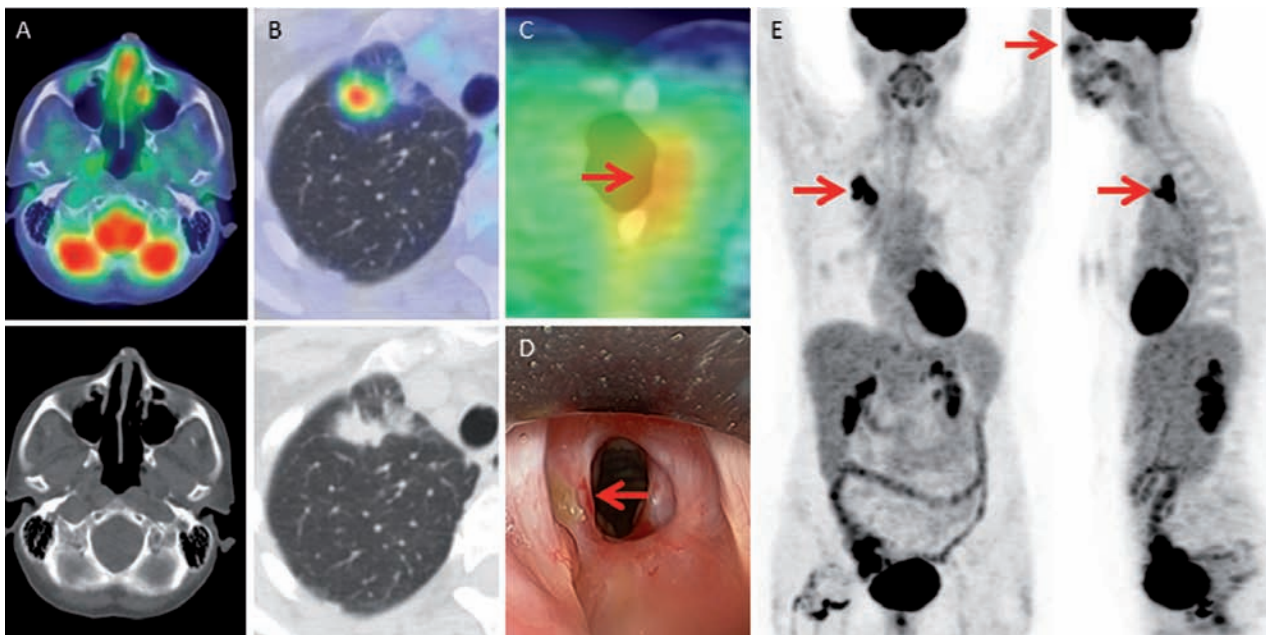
PET/CT in Recurrent GPA. Multifocal disease seen on PET/CT fits a pattern highly suggestive of GPA in this patient (no. 3) with recurrent GPA disease, including FDG avid lung, sinus and tracheal disease. Moderate FDG activity in the nasal mucosa with no clear underlying mass seen on axial PET/CT (A) and sagittal MIP PET image (E, arrow). Multiple intensely FDG avid solid and part-solid lung nodules seen on axial PET/CT (B) and MIP PET images (D, arrows). Mild activity in the left subglottic trachea seen on axial PET/CT (C, arrow) matches a focus of biopsy proven recurrent GPA in the airway seen on bronchoscopy (D, arrow, patient airway is viewed from above/cranial and therefore flipped in relation to the orientation of PET/CT). This patient had prior GPA in the trachea and previous interventions to diagnose and treat this process. Activity in the right hip seen on MIP PET images (D) is related to a healing THA. This patient with recurrent GPA did not show the diffuse splenic and bone marrow activity sometimes seen in the cases of newly diagnosed GPA
